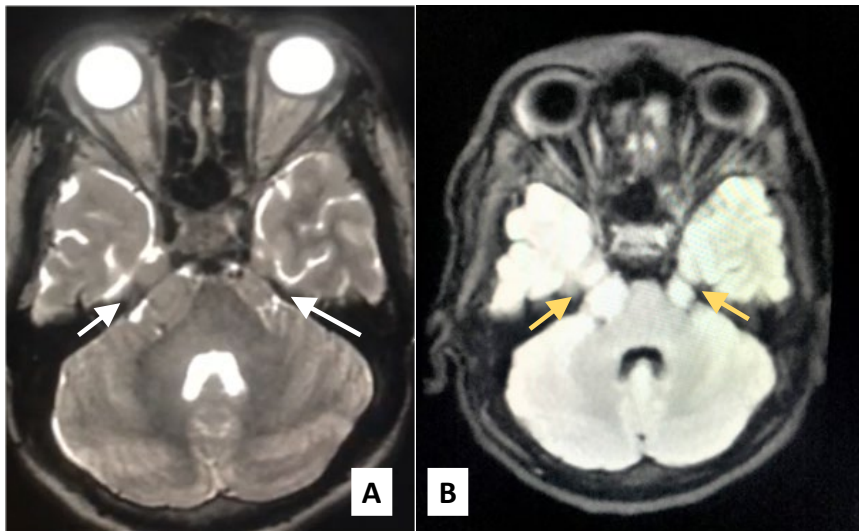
MRI showing multiple focal lesions in both cerebellopontine angle regions and pontomedullary cistern areas. Right: 1.1 x 1.8 x 1.3 cm Left: 0.8 x 1.6 x 0.6 cm. A. Brain MRI T2. B. Brain MRI T2 Flair
